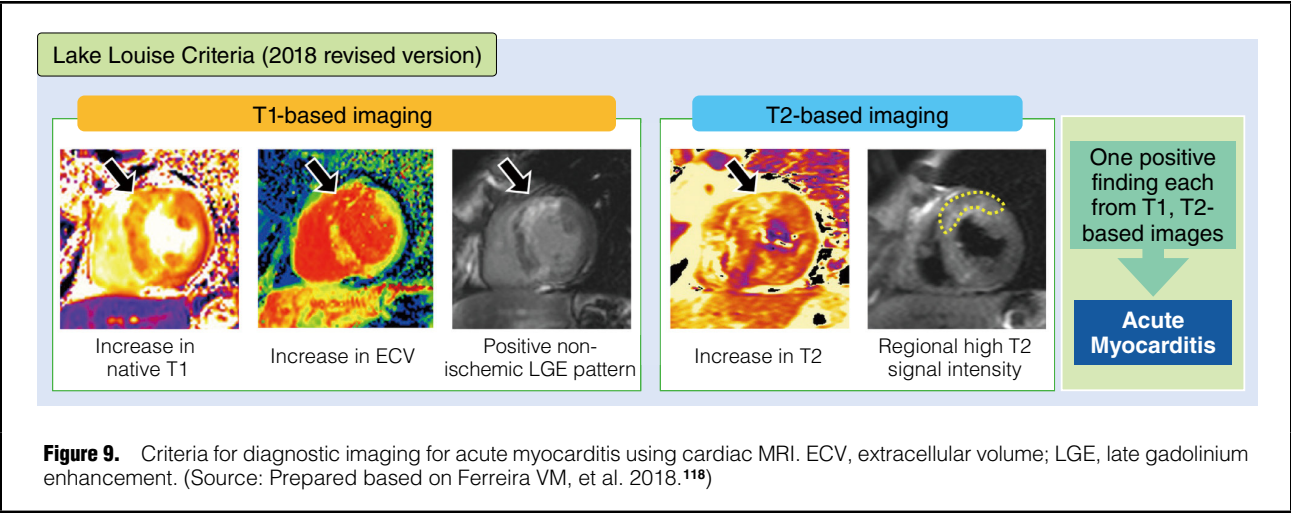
Criteria for diagnostic imaging for acute myocarditis using cardiac MRI. ECV, extracellular volume; LGE, late gadolinium enhancement. (Source: Prepared based on Ferreira VM, et al. 2018.¹¹⁸)
